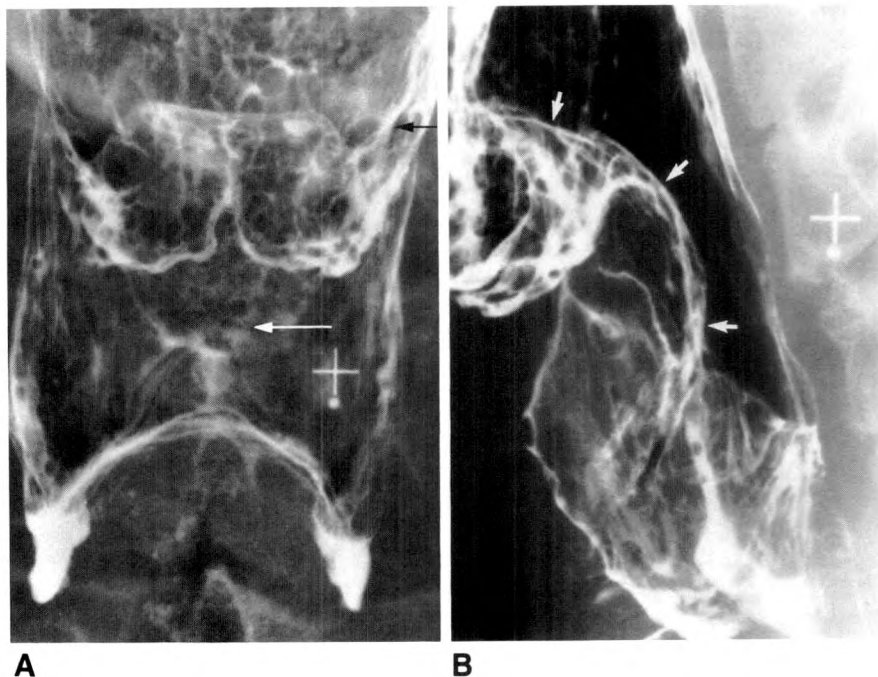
Frontal and lateral radiographs in 64-year-old man with squamous carcinoma of epiglottis.
